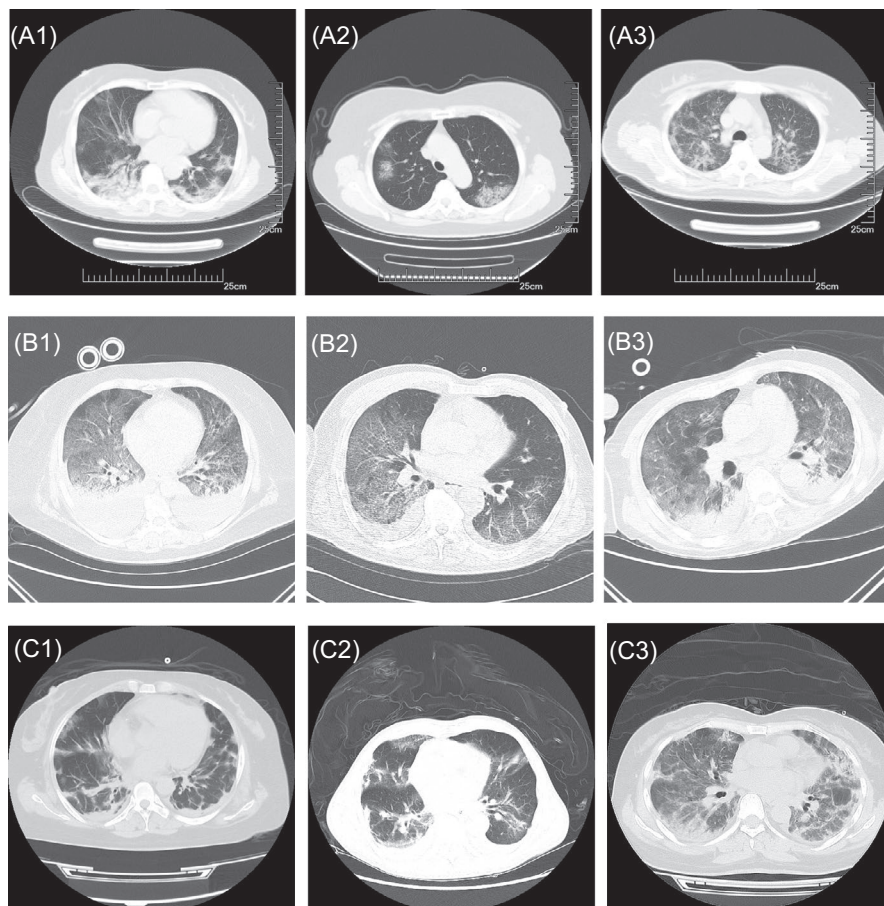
Representative chest CT images of severe/critically ill patients with COVID-19, influenza A H7N9, and H1N1
